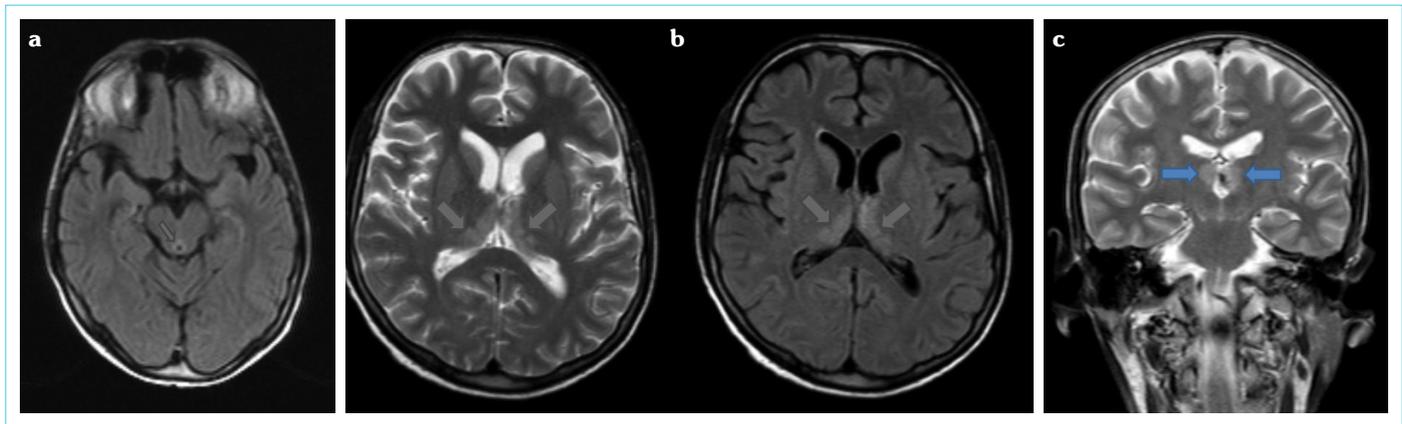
a–c. (a) A hyper-intensity was observed in the surrounding aqueduct on an axial FLAIR sequence. (b) On axial T2-weighted and FLAIR images, a symmetrical, bilateral hyper-intensity was observed in the subthalamic nucleus localization at dorsomedial of thalamus. (c) A symmetrical, bilateral hyper-intensity was observed in the subthalamic nucleus localization at dorsomedial of thalamus on coronal T2-weighted images
